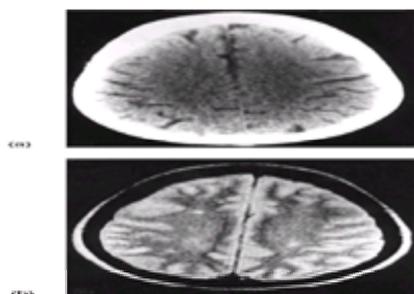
Equivalent brain sections seen on CT scanning (a) and MRI scanning (b) in a patient with neuropsychiatric disease. Although some widening of the sulci is seen in (a), several discrete ischaemic areas are present in (b) which are not demonstrated on CT scanning.
